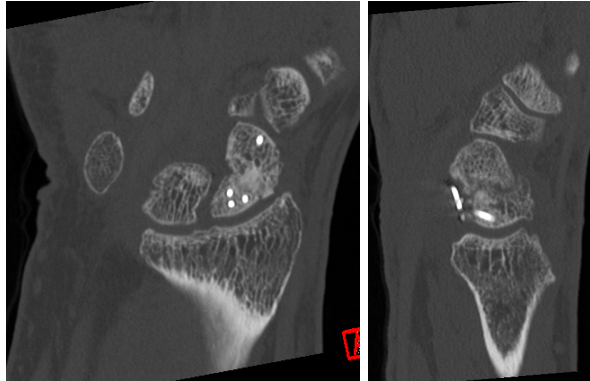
Case 8: CT scan 2017 (post surgery)
